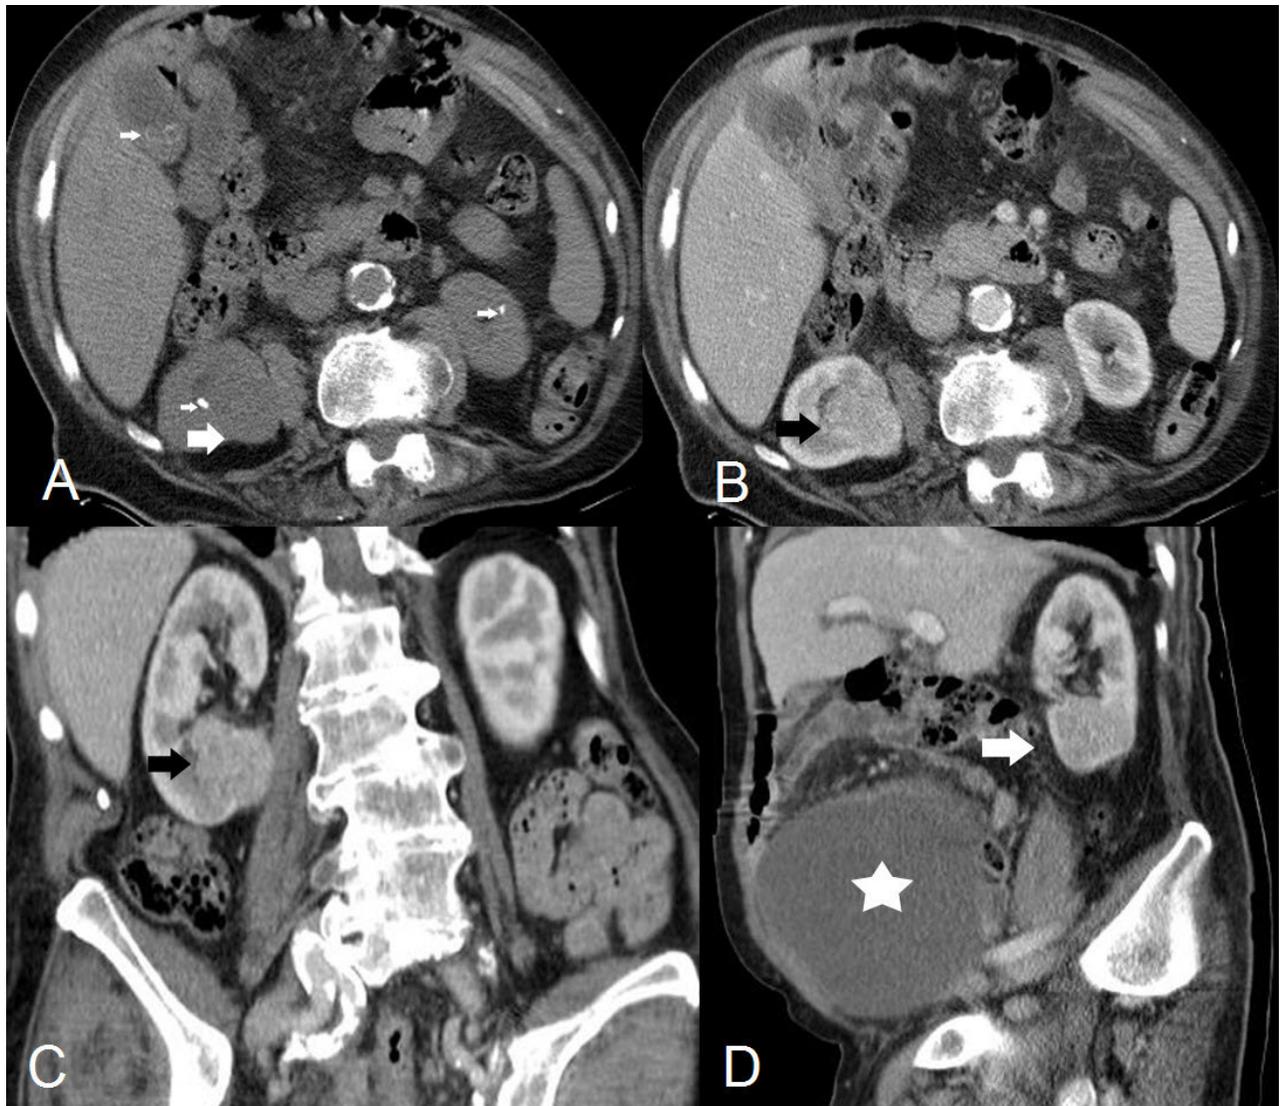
(a) Transverse plain CT image depicts a lower pole right renal mass (arrow). Renal stones and gall bladder stones (small arrows). (b) Transverse and (c) coronal reformatted CT images show the tumor strongly and inhomogeneously enhancing (arrow). (d) Sagittal MPR depicts both the renal (arrow) and the pelvic mass (asterisk).
